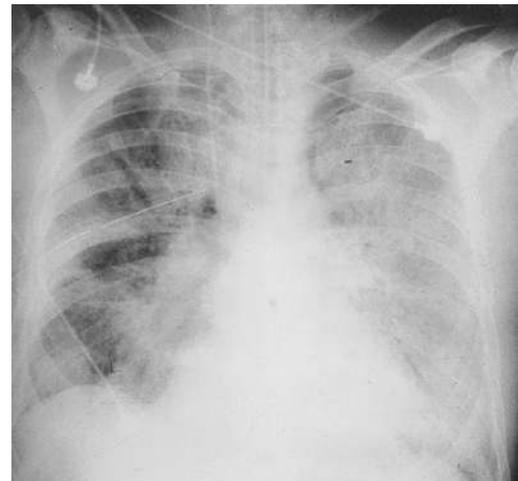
Representative Chest Radiograph from a Patient with Acute Respiratory Distress Syndrome.
